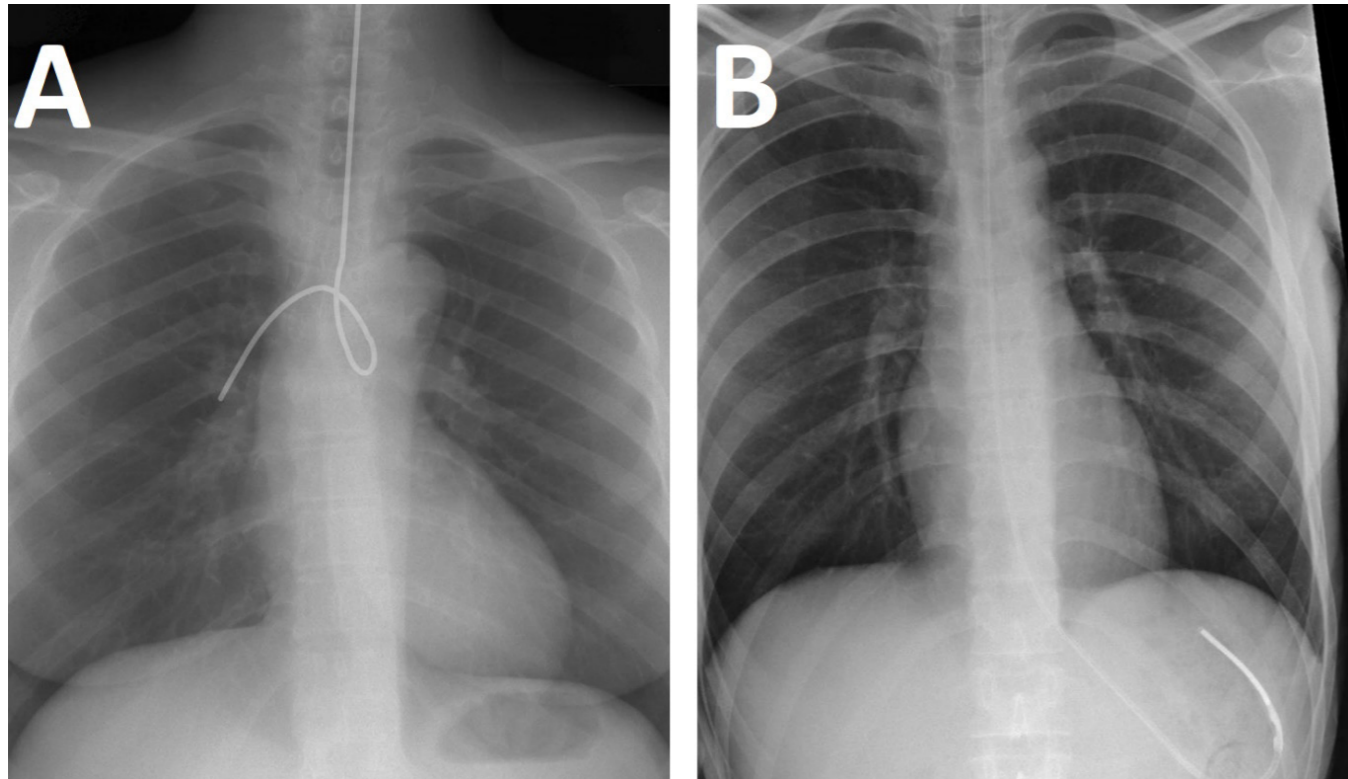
Two images of chest x-rays with image A showing an incorrect NG tube placement (tube coiled in the Tracheobronchial Tree) and image B showing correct placement (to the correct length) of the NG tube.
